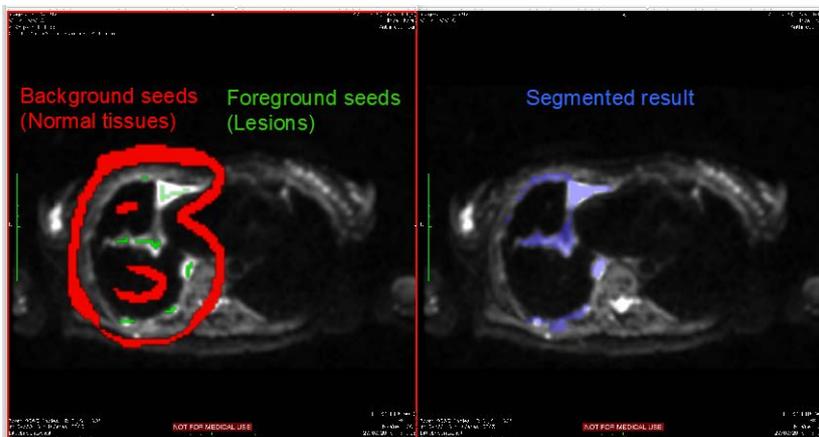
Demonstration of the implement of GrowCut segmentation tool on one axial slice of DWI ($b = 100 \text{ s/mm}^2$) image of a 64-year-old male patient with malignant mesothelioma in the right lung. In the left-hand side image, the foreground seeds (Green) were drawn in MPM lesions while the background
